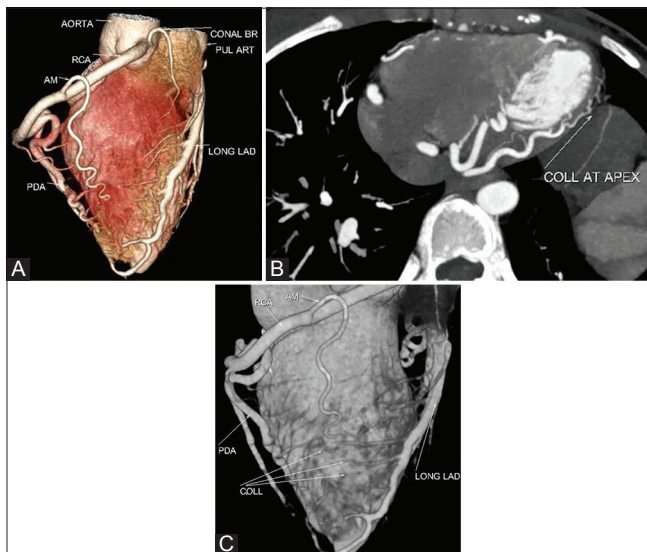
(A-C): (A) Volume-rendered image showing dilated, tortuous right coronary artery, acute marginal branch and terminal branch PDA (B) Axial image shows multiple tortuous collaterals along the epicardial surface (C) Volume-rendered CT angiogram images showing bridging collaterals between PDA and long LAD
